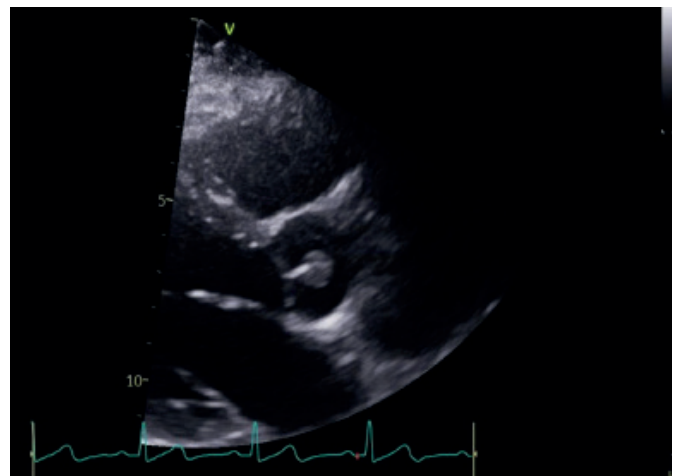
Transthoracic echocardiography (TTE) Parasternal long-axis view demonstrating a mass attached to the aortic valve.
